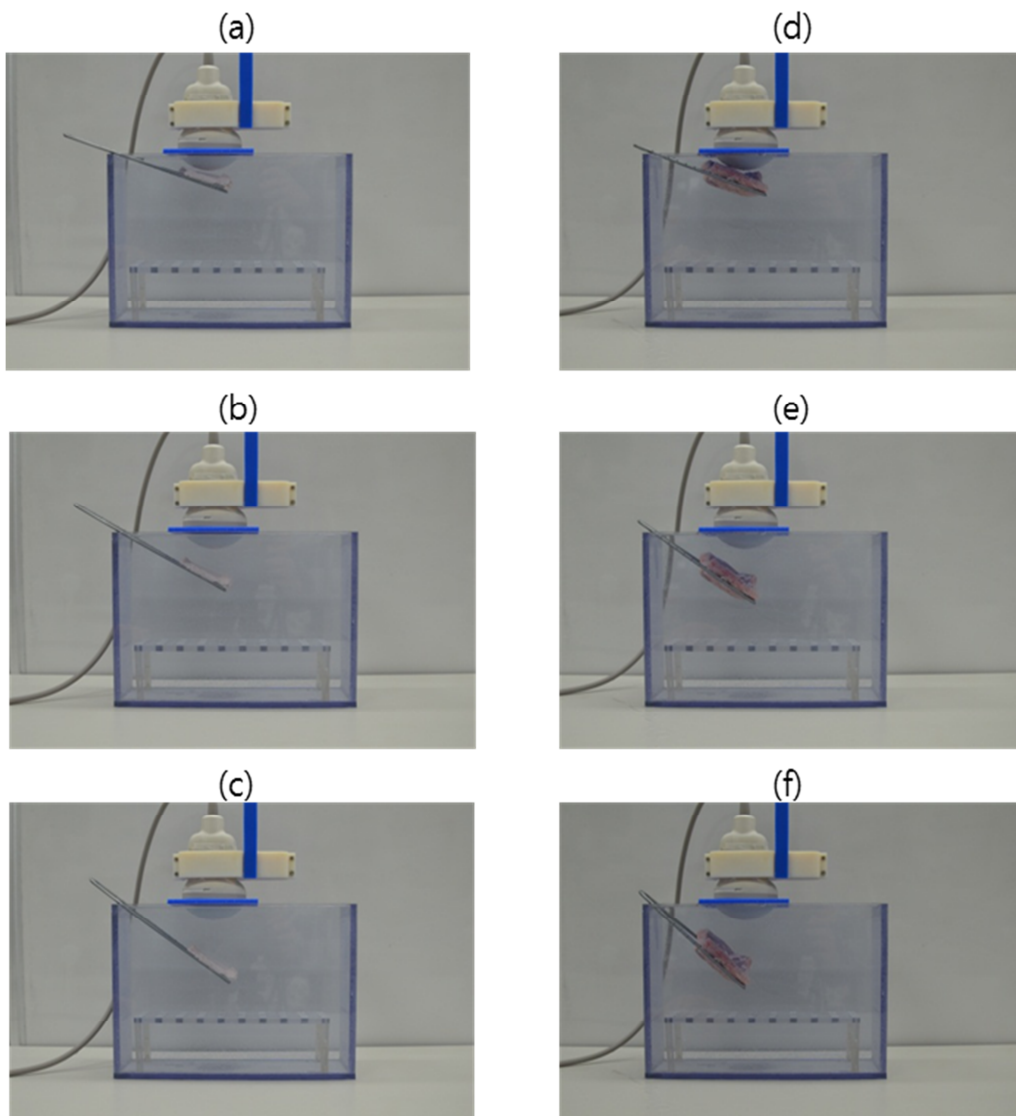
Experiment setup for examining ultrasound refraction (a) Fat 15° (b) Fat 30° (c) Fat 45° (d) Muscle 15° (e) Muscle 30° (f) Muscle 45°
